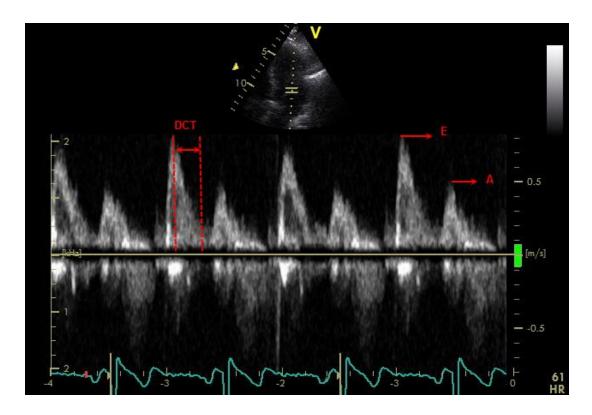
3 Mitral Inflow Pulse Wave Doppler (PWD) echocardiography. DCT = deceleration time, E = peak early diastolic inflow velocity, A = peak late (atrial phase) diastolic inflow velocity.
